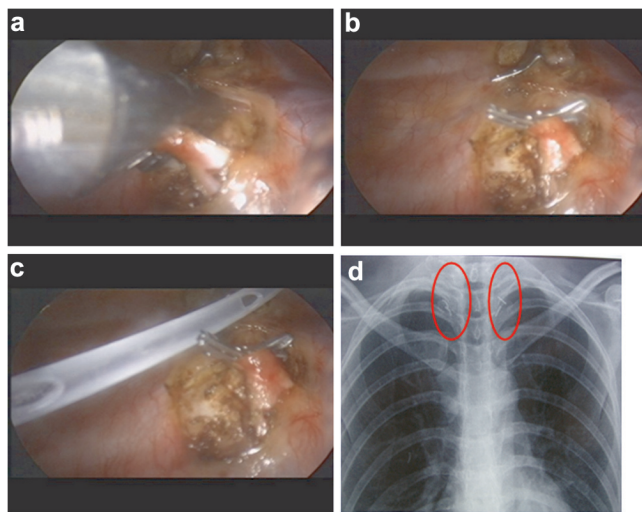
(a) Endoscopic clip application with the U-shaped applier. (b) Aspect of the SN double clipped. (c) Pleuro-cath drain placed at the end of surgery. (d) Clips visible in the postoperative chest-X-ray. SN, sympathetic nerve.
